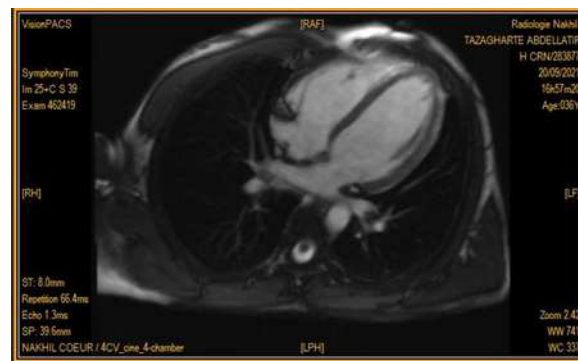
4 chamber view on Cardiac MRI
